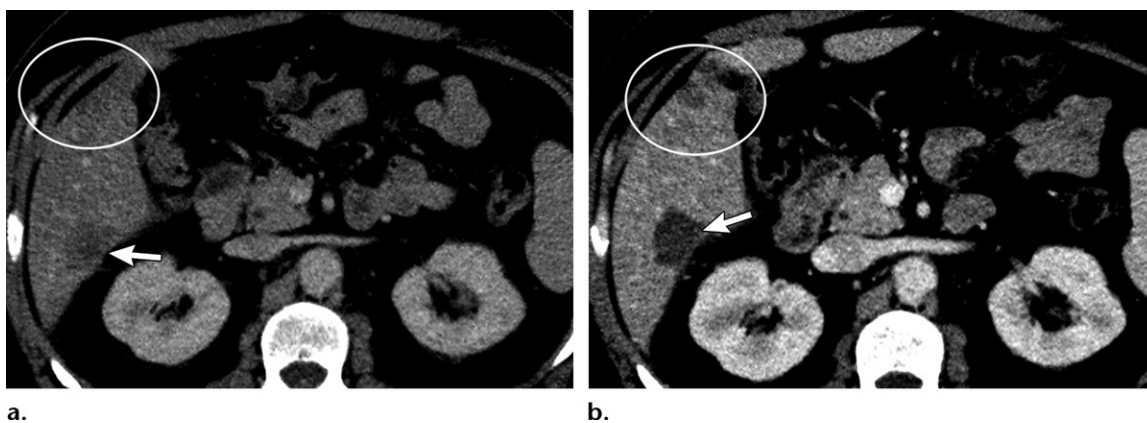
Pseudoprogession of disease in a 60-year-old man with colorectal liver metastases. (a) Axial portal venous phase CT image shows liver metastasis (arrow) in liver segment VI. (b) Axial posttreatment portal venous phase CT image shows an apparent new lesion (circle) in liver segment V caused by devascularization of a lesion that was poorly seen (circle in a) at pretreatment CT. Note the complete necrosis (arrow) of the segment VI metastasis after treatment.
